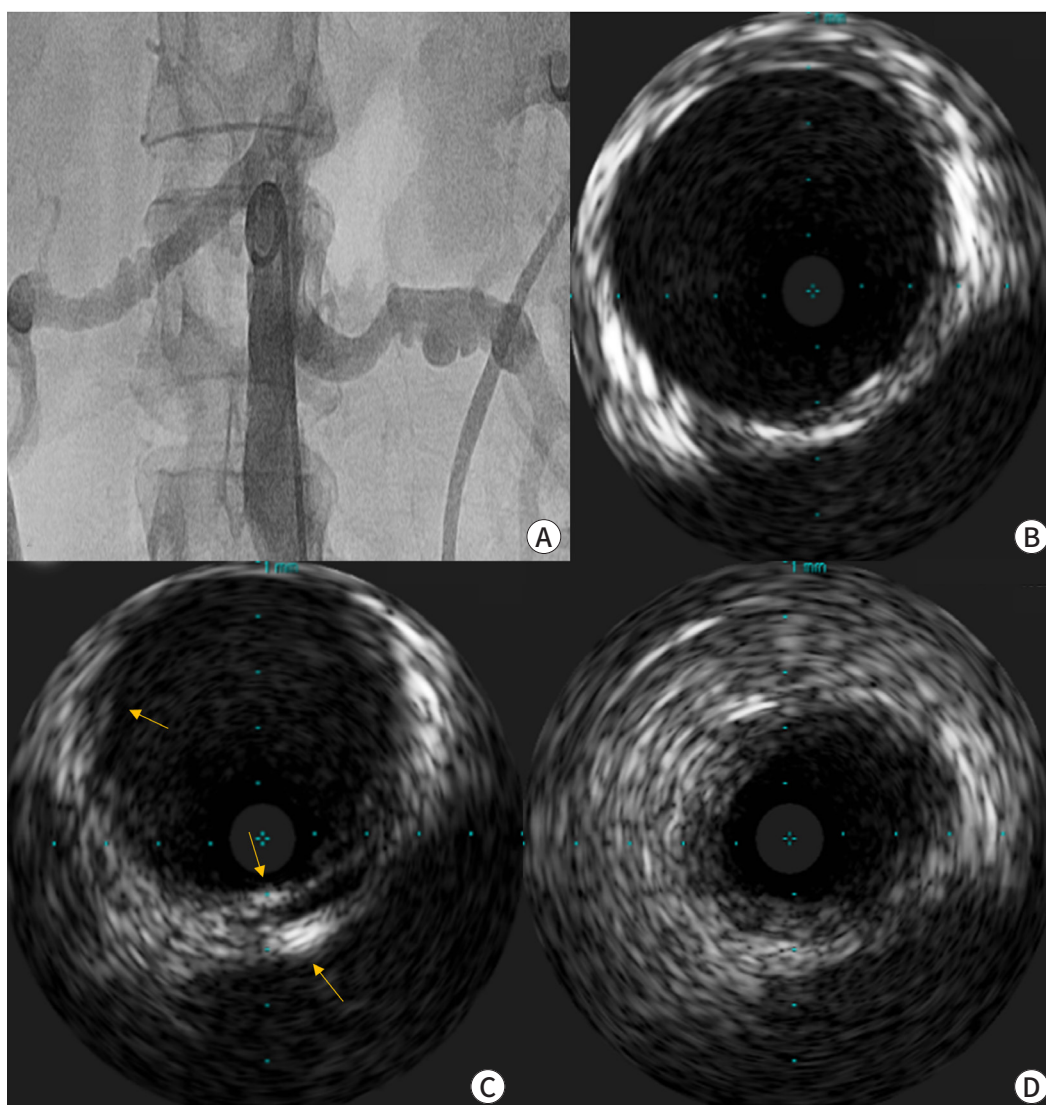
Invasive images of the renal arteries. (A) Angiography reveals the typical “string of beads” appearance in both renal arteries. Intravascular ultrasonography indicates varied disease progression. (B) The vessel layers are relatively preserved. (C) There is an intimal fibromuscular ridge and increased medial echogenicity, as indicated by the arrows. (D) Circumferential hyperplasia of the intimal or medial layers is noted, accompanied by denudation of the vessel layers.
